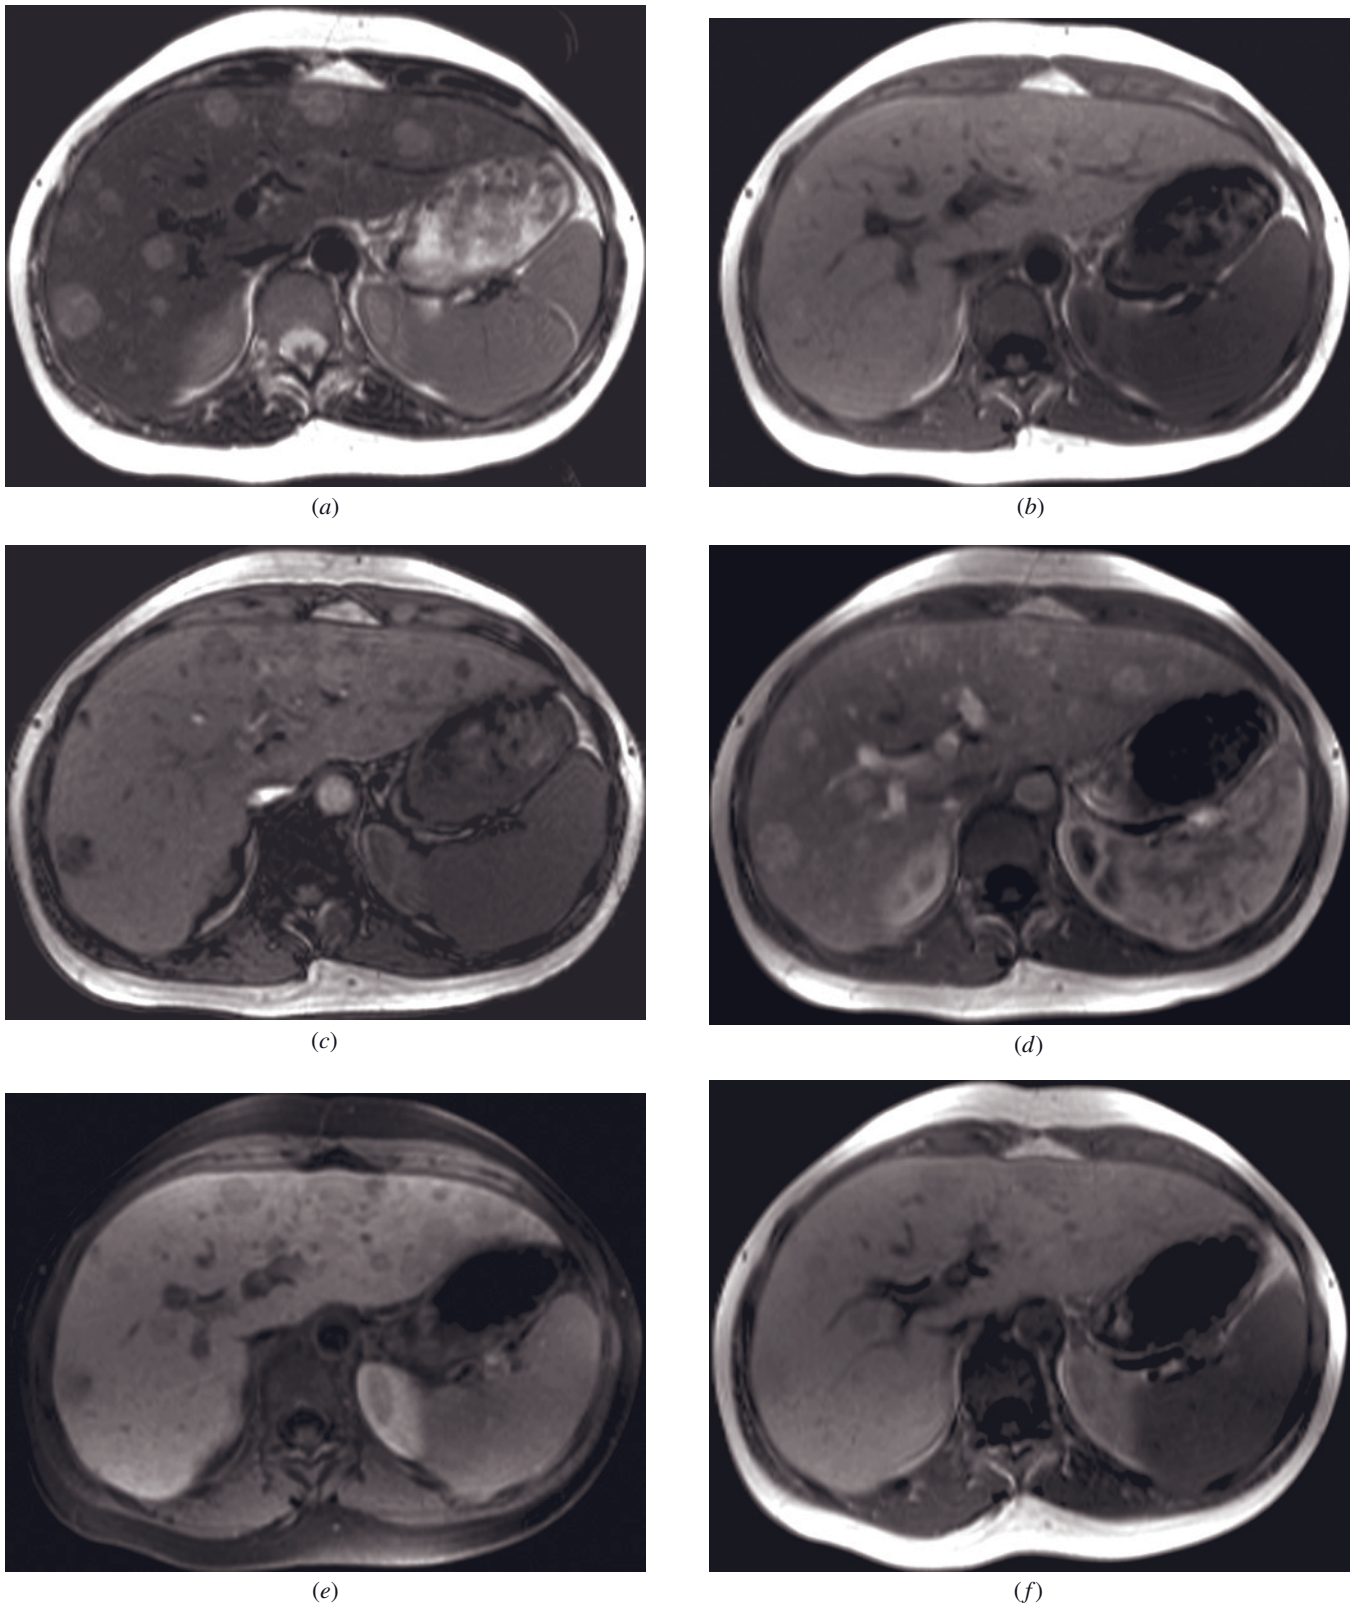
Adenomatosis, Gd-BOPTA. T2-weighted SS-ETSE (a), SGE (b), out-of-phase SGE (c), and immediate (d), 90-s fat-suppressed (e), and 1-h (f) SGE after administration of Gd-BOPTA. Multiple lesions with varying sizes are seen in the hepatic parenchyma. These lesions demonstrate moderately high signal intensity on the T2-weighted image (a), isointensity on the T1-weighted image (b), drop in signal intensity on the out-of-phase image (c), and intense enhancement on the early phase image (d). On the late-phase image (e) these lesions show low signal intensity partially due to the fat suppression effect of this sequence. One hour (f) after administration of contrast, the lesions are low signal relative to liver, suggesting that there is no uptake of the contrast by the hepatocytes. This finding is consistent with adenomatosis and rules against multiple FNHs. (Courtesy of Guenther Schneider, M.D., Ph.D., Dept. of Diagnostic and Interventional Radiology, University Hospital Homburg/Saar, Germany).
